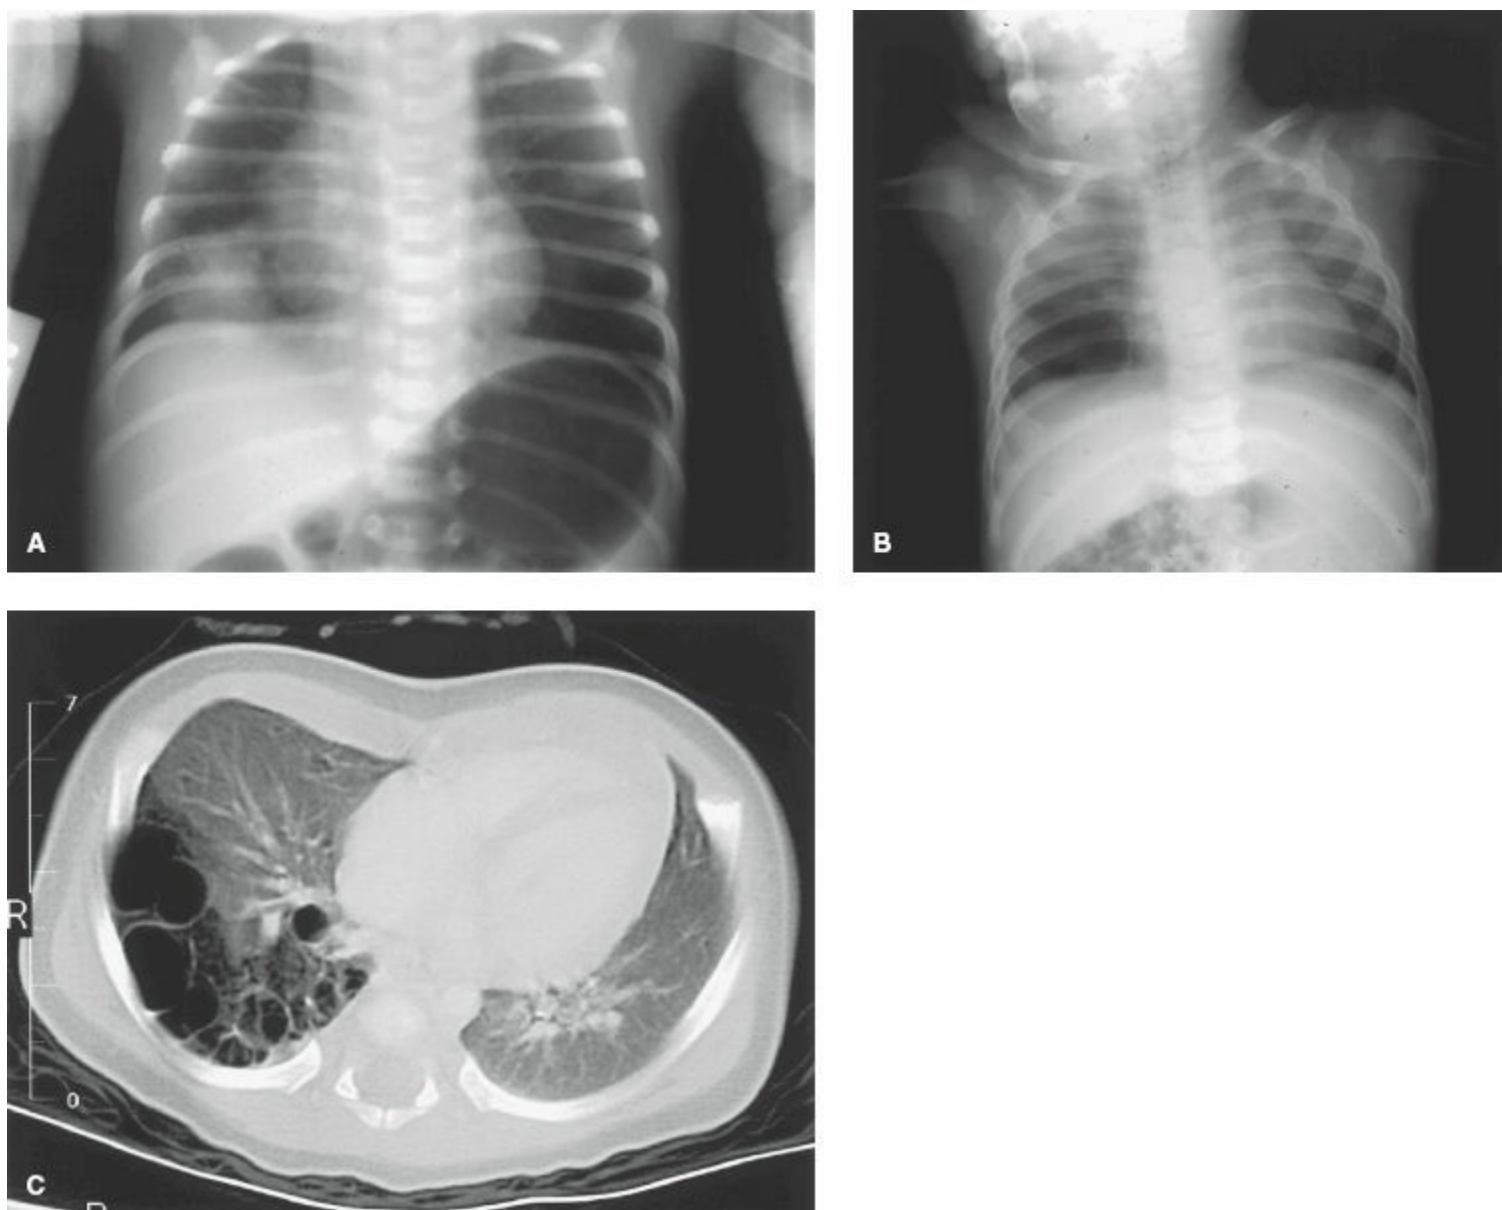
Congenital cystic adenomatoid malformation (CCAM). A: Newborn chest x-ray of a patient with prenatal diagnosis of CCAM. Note that immediately after birth, the mass is fluid-filled and appears as a density in the right hemithorax. B: Chest x-ray of the same child at 5 months of age prior to surgical excision. Note the air-filled cystic appearance of CCAM. C: Transverse thoracic computerized tomographic view of CCAM.
